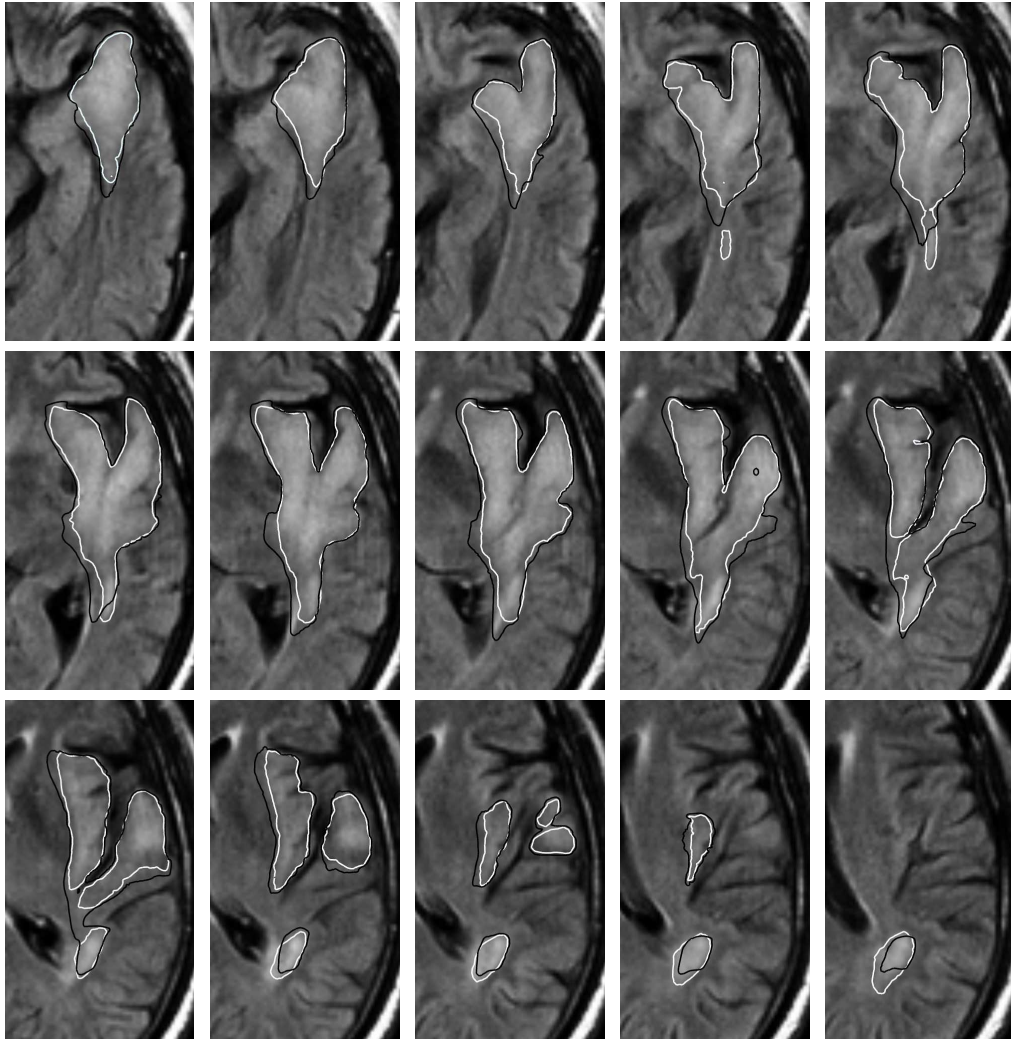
The MR image taken at the fifth time point for the second patient. The white contour denotes the manual delineations and the black contour is the estimated evolution of the tumor delineation.
